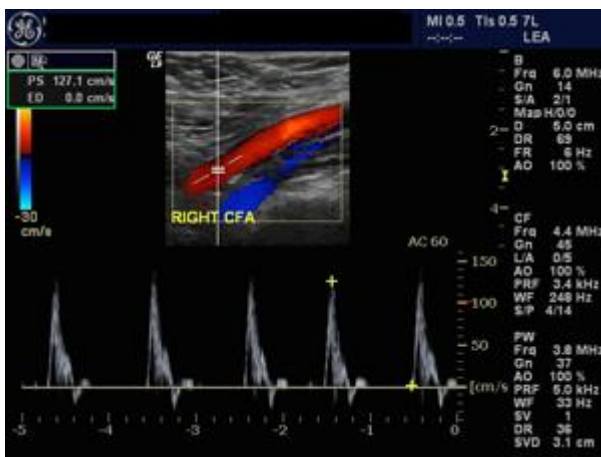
Color and Spectral Doppler image of Right Common Femoral Artery
